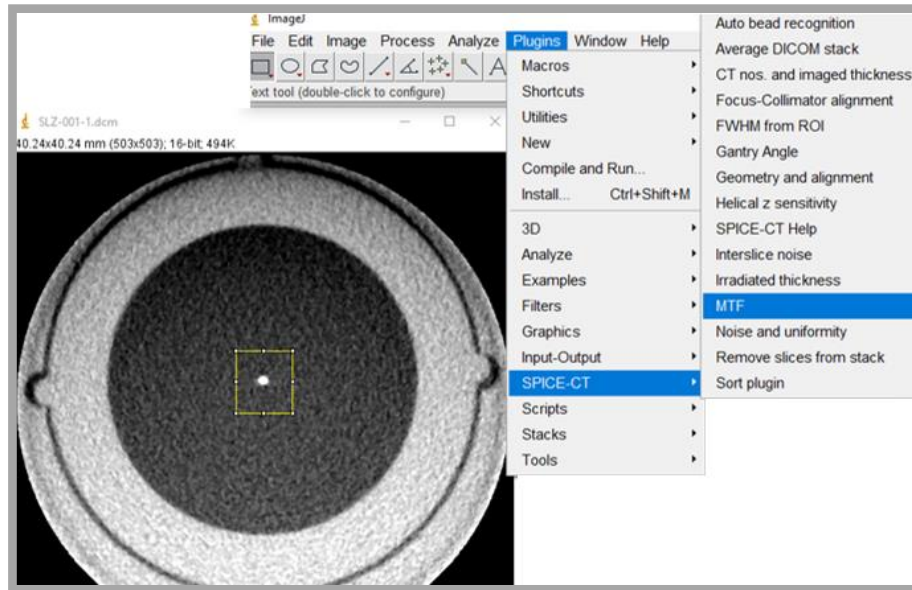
Calculation of MTF: DICOM files exported into ImageJ of the scanned PSF inserts enabled calculation of 10% MTF using open source SPICE-CT plug-in.
